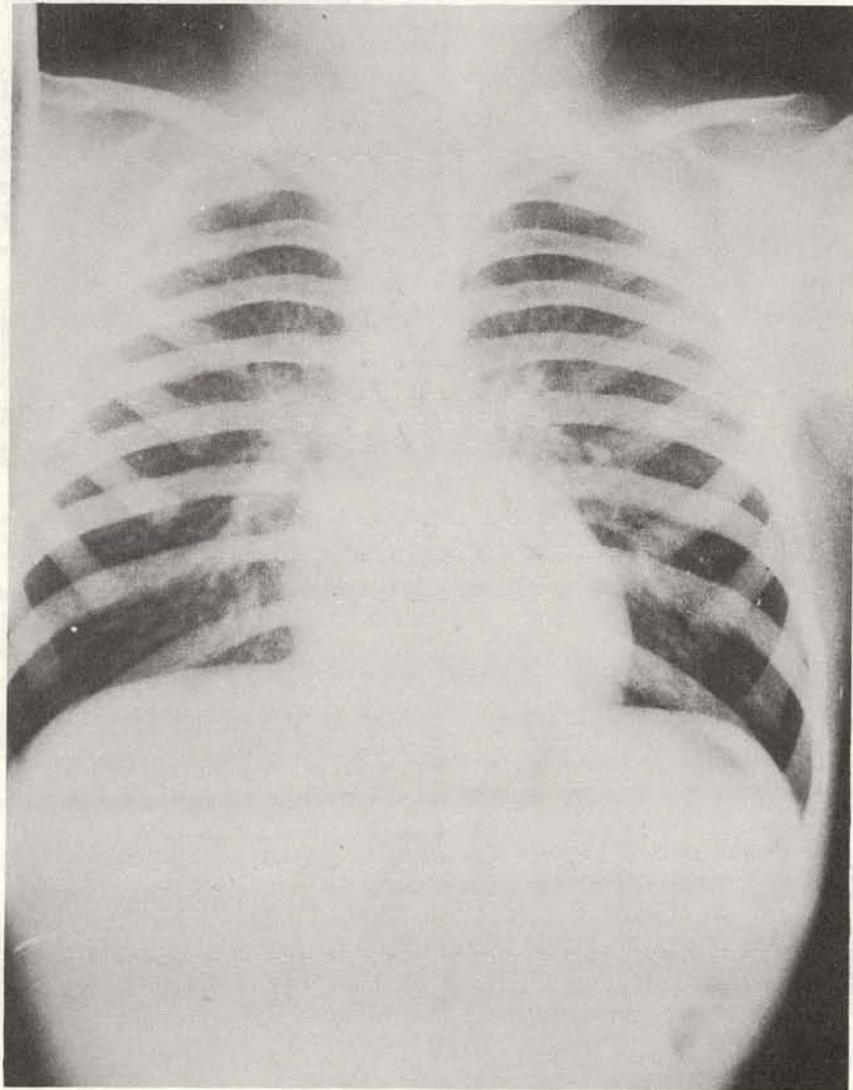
Roentgenograph of chest of same patient as is shown in Figure 53. Note complete clearing of the pulmonary metastases with I^{131} .
